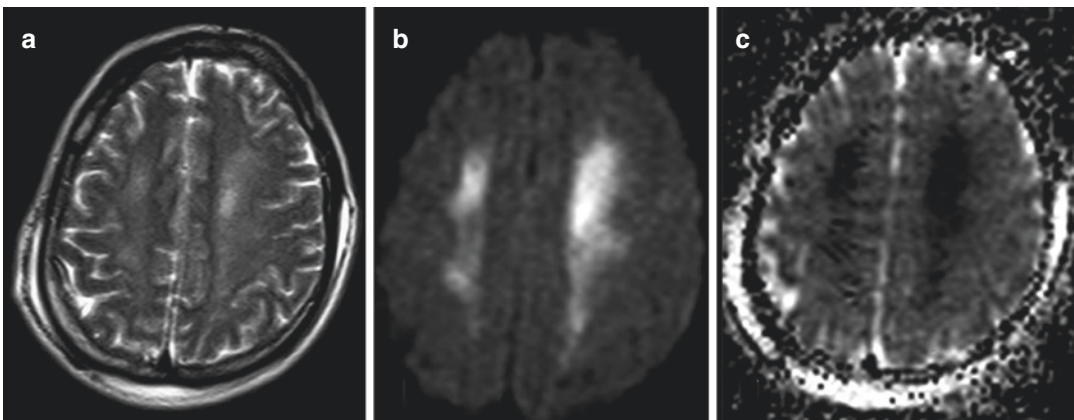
Spongiform encephalopathy with cytotoxic oedema of the supratentorial white matter (a: T2-weighted fast spin echo, b: DWI, c: ADC images) in a 28-year-old heroin abuser. As the cerebellum was not affected and heroin was not inhaled, the admixture of an adulterant such as levamisole possibly caused the leukoencephalopathy
